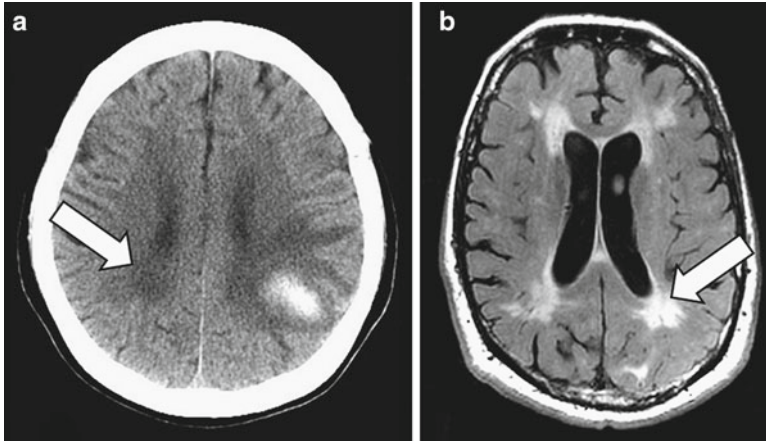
Leukoaraiosis appears on CT as periventricular white matter hypodensities in this patient with a left parietal lobar ICH (a, *arrow*), and on T2-weighted MRI as hyperintensities (different patient) (b, fluid attenuated inversion recovery [FLAIR] sequence, *arrow*)
